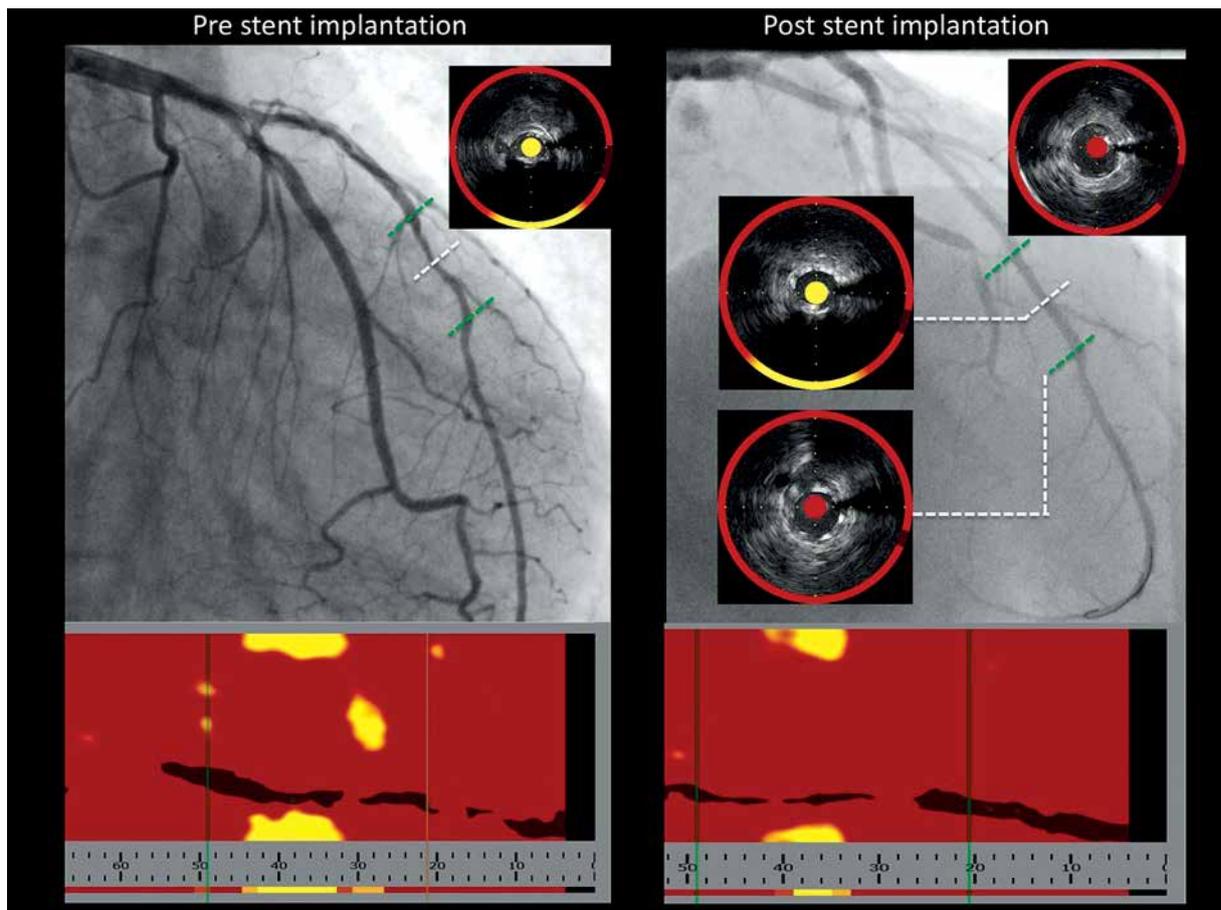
Case example of the combined near-infrared spectroscopy and intravascular ultrasound imaging
